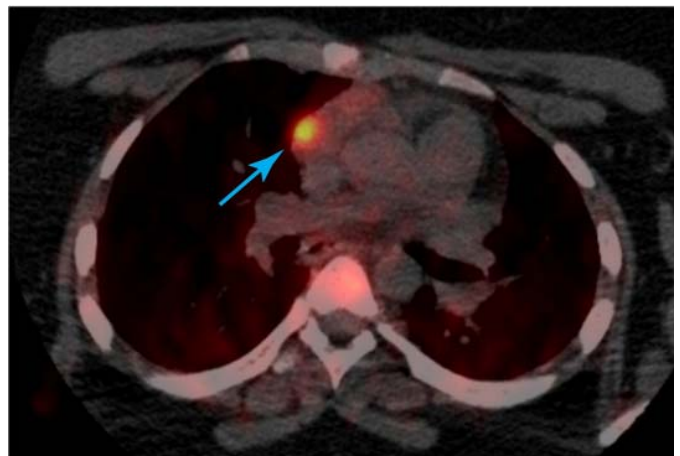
PET-CT scan of an adenoma in the paracardiac position
